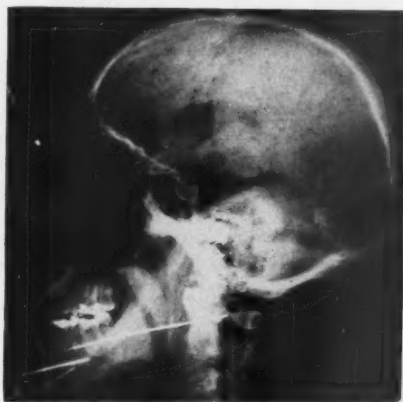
Symphysis and angle fractures of mandible treated by internal Kirschner wires. Note multidirectional wires at symphysis. Posterior wire is too high and was removed after x-ray.
